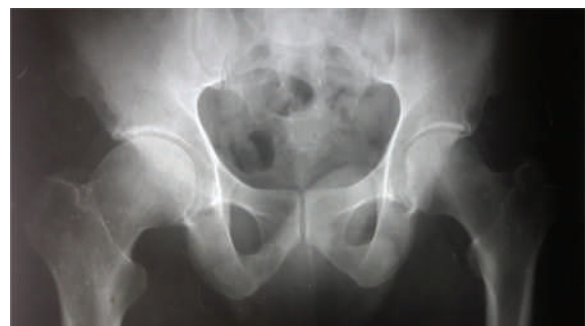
X-ray pelvis taken at the time of onset of hip pain
